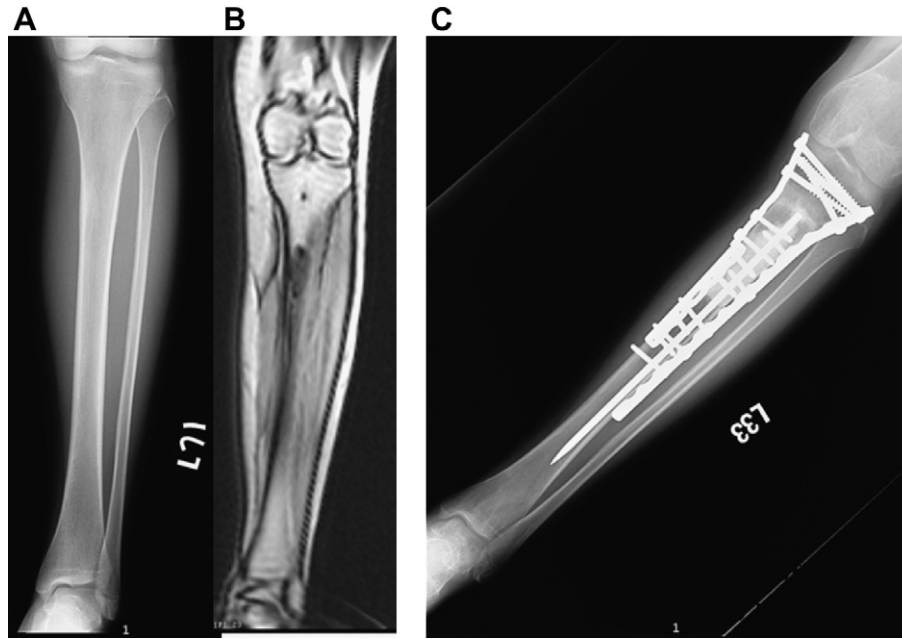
A 23-year-old woman (Case 10) with Ewing sarcoma of the left tibia received wide excision surgery with recycled autograft reconstruction. (A) Plain radiograph showing an osteolytic lesion with cortex invasion of the left tibia; (B) magnetic resonance imaging revealed an osteolytic lesion of the left proximal tibia; (C) plain radiograph of the left tibia after wide excision surgery and recycled autograft reconstruction.
